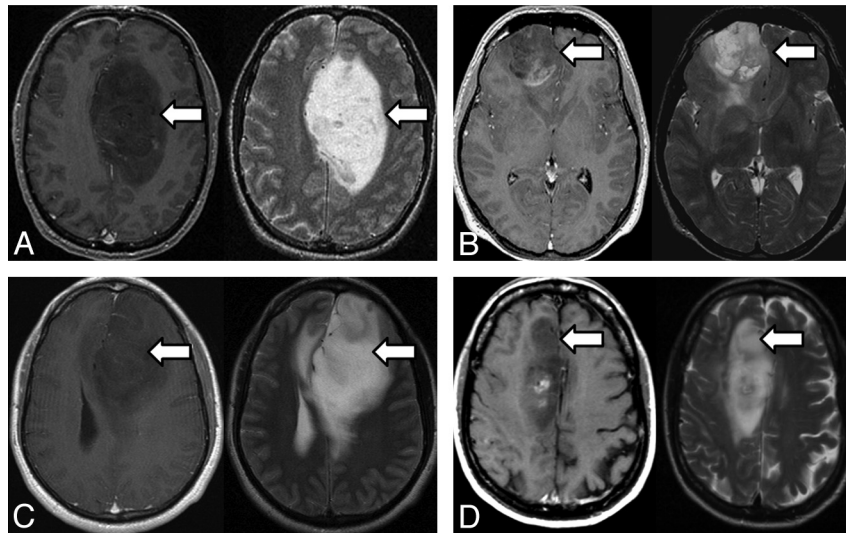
A–D, Four examples of *IDH1* mutant tumors on MR imaging. For each set of paired images, T1 postcontrast images on the left are shown with the corresponding T2-weighted image on the right. Note abundant nonenhancing tumor (arrows) and frontal lobe location.
